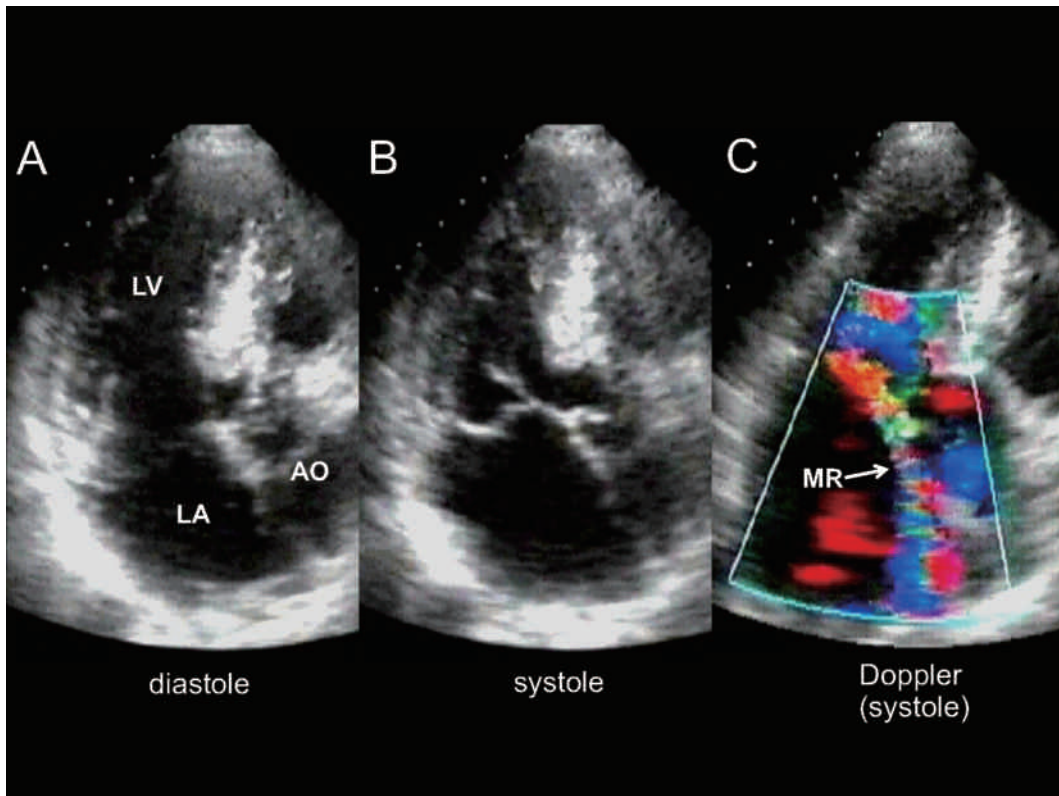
Echocardiographic images in transthoracic apical long axis view four years after the first presentation. A, Two-dimensional image on diastole. B, Two-dimensional image on systole. There was no systolic anterior movement of the anterior mitral leaflet, and the outflow tract was not obstructive. The posterior mitral leaflet bulged into the left atrium. C, Color Doppler flow image on systole. The jet of severe mitral regurgitation was oriented anteriorly. AO=aorta; LA=left atrium; LV=left ventricle; MR=mitral regurgitation.
